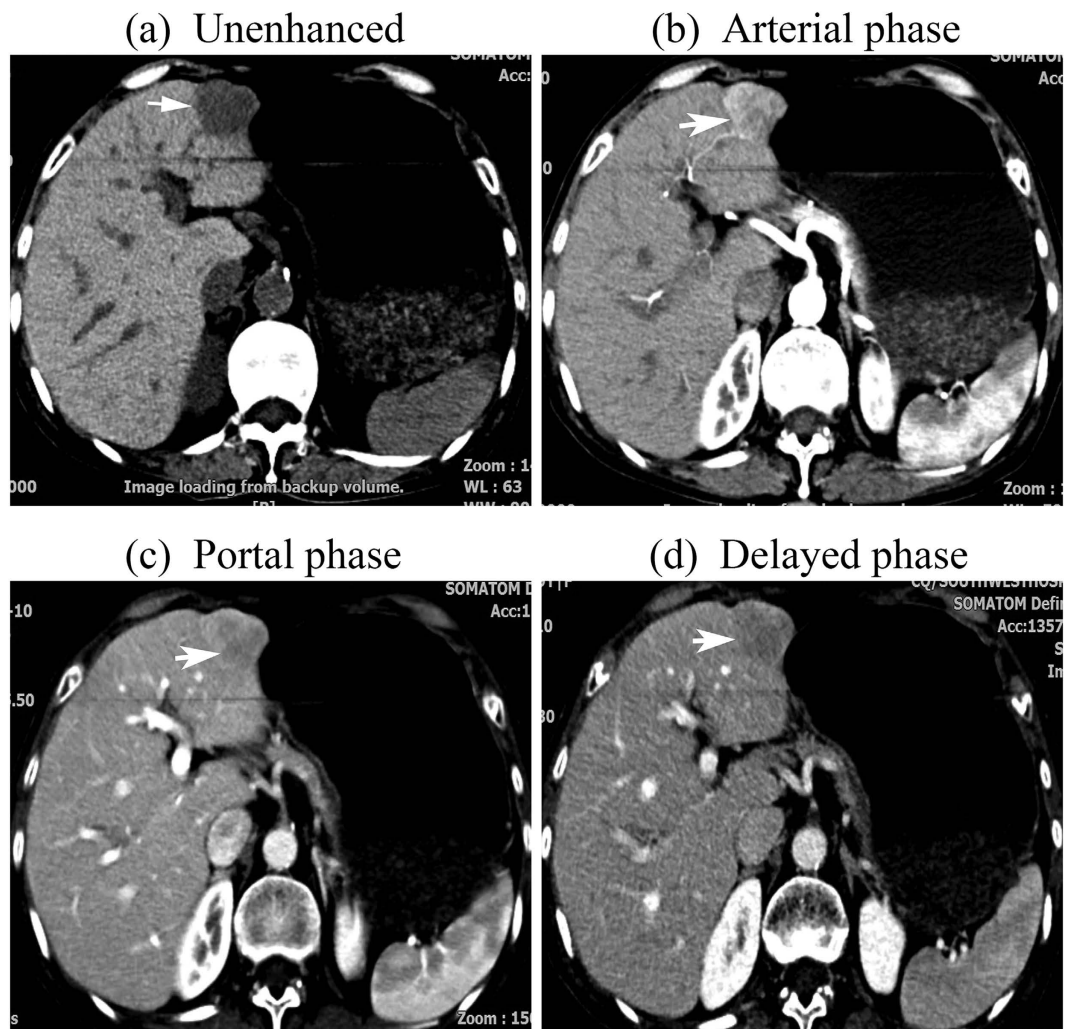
tif CT images of a 69-year-old woman with a 2.7-cm -diameter ICC displaying wash-in and wash-out enhancement pattern. The nodule was hypodense at unenhanced CT (a). After intravenous contrast administration, the nodule shows marked hyper-enhancement during the arterial phase (b) followed by wash-out during the portal phase (c) and the late phase (d) (arrow).
